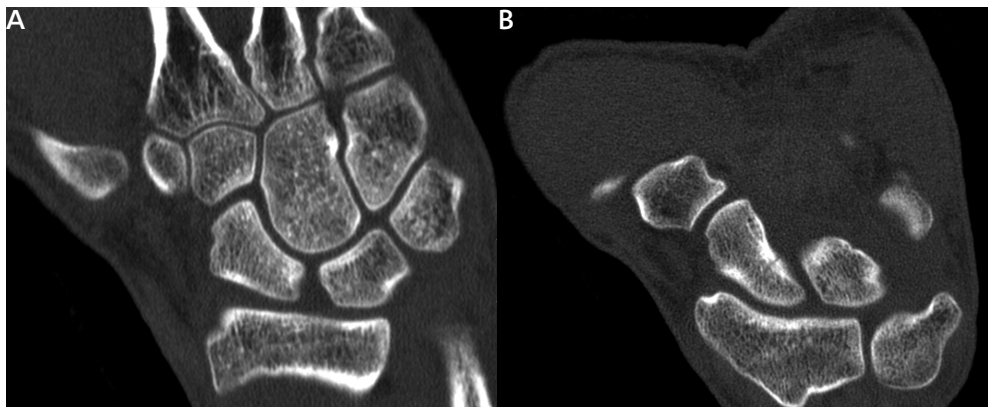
(A) No fracture visible on CT scan reformatted in the plane of the wrist (CT-wrist). (B) The same patient did show a fracture on CT scan reformatted along the longitudinal axis of the scaphoid (CT-scapoid).
